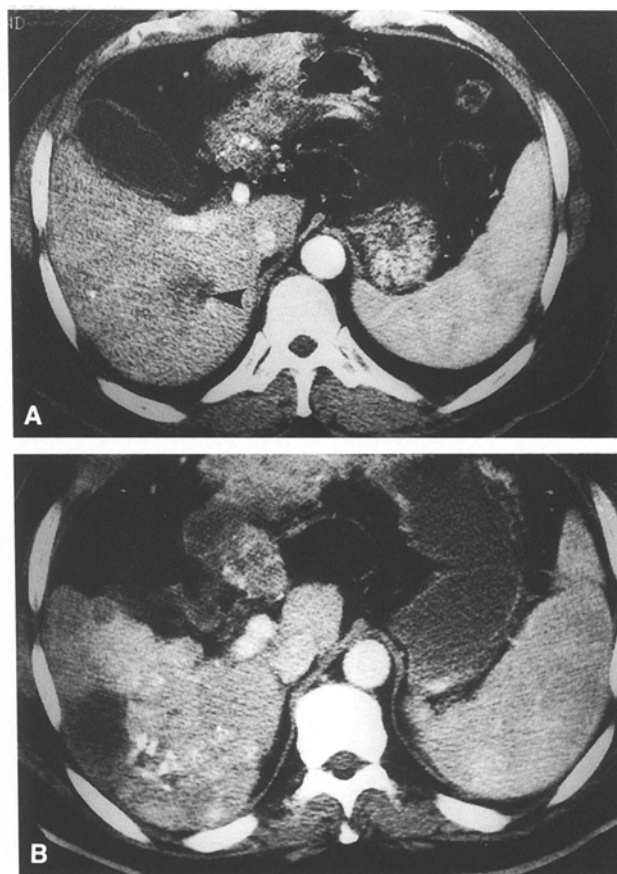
A 41-year-old man with diffuse hypovascular hepatoma treated by iodized oil/cisplatin. A Contrast-enhanced CT before treatment shows an indiscreet mass with portal vein thrombus (*arrowhead*). The patient experienced sudden abdominal pain and fever, and abdominal CT was obtained. B Contrast-enhanced CT 1 week after TAE shows an irregularly shaped hypodensity area in the posterior segment of the right lobe. The patient was treated conservatively. The patient died 3 months after TAE and the liver infarction was demonstrated at autopsy.
